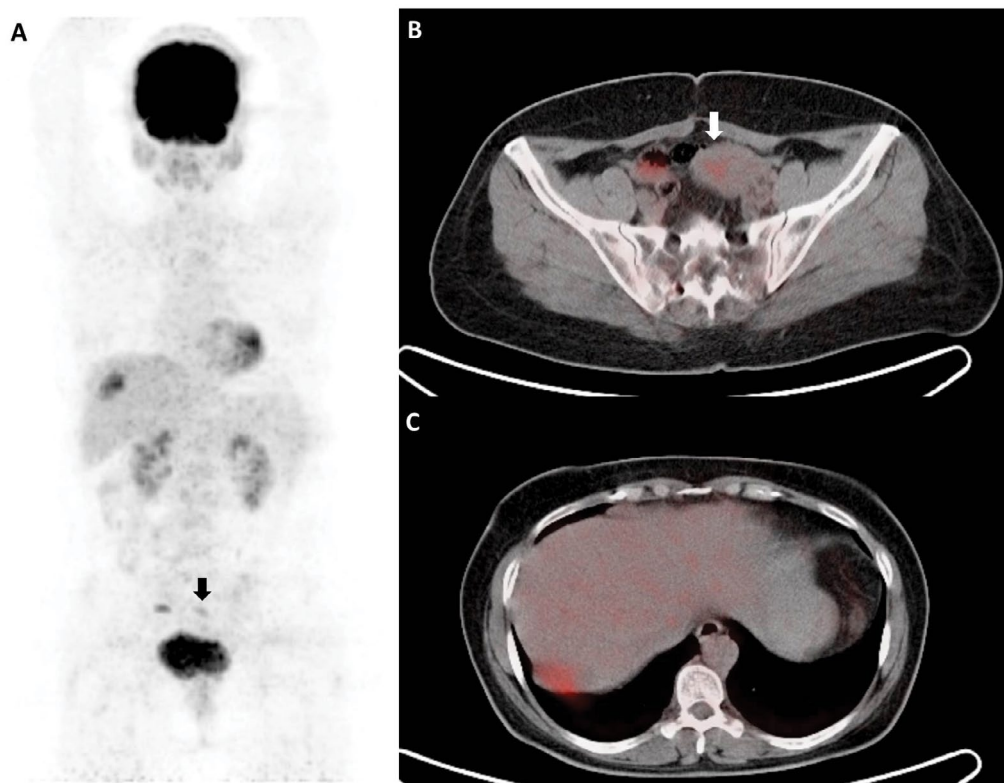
The MIP (A) and selected axial PET/CT (B, C) images of a 56-year-old patient with stage 4B undifferentiated endometrial cancer and a capsular implant in the liver are presented. Among the PET parameters of the primary tumor of the patient (A,B; arrows), SUVmax, SUVmean, MTV and TLG were found to be 3.8, 3, 1.2 mL and 3.6 g, respectively. The progression-free survival and overall survival of this patient were 6 months and 17 months, respectively
